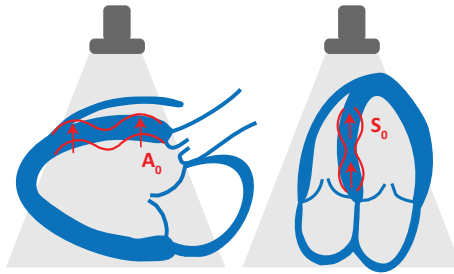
In parasternal long-axis view, mainly transversal particle motion is measured (left), while in apical 4-chamber view mainly longitudinal particle motion is measured (right) because of the angle dependency of TDI. It could be expected that if an A_0 -mode and a S_0 -mode are induced by the AVC, the A_0 -mode dominated by transversal motion is mainly measured in parasternal view, while the S_0 -mode is mainly measured in apical view.
